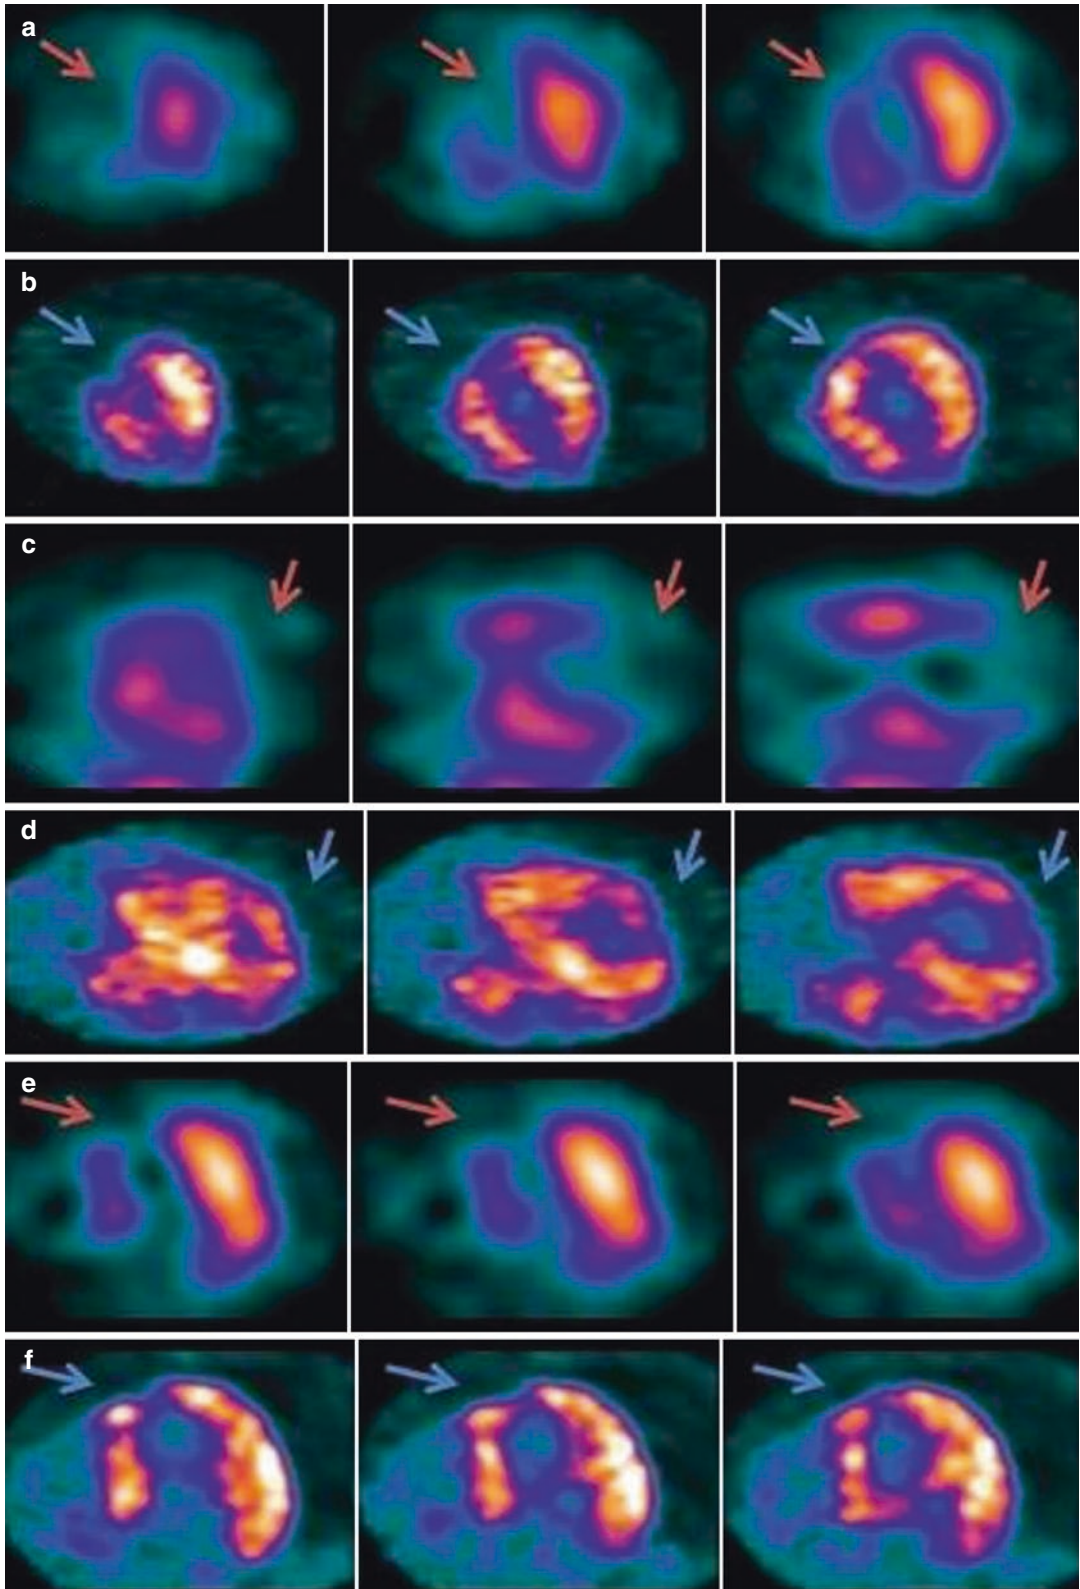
Myocardial SPECT (a, c, e) shows perfusion deficit in the apex of the left ventricle; correlative myocardial PET with ¹⁸F-FDG (b, d, f) displays tracer uptake in the apex, indicative of myocardial viability
